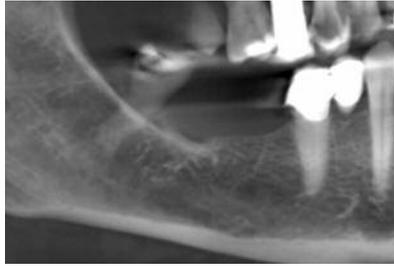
Control Preoperative radiography of alveolar preservation.
